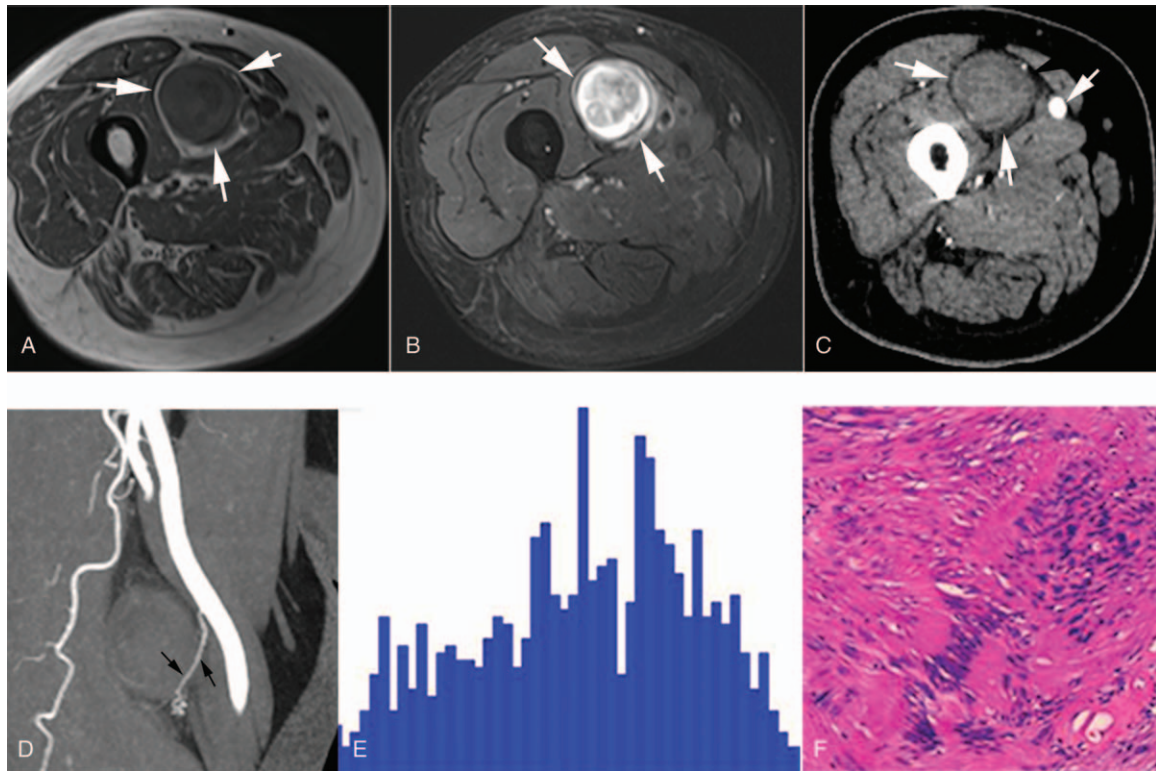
An 84-year-old man with a right thigh mass. T1 and T2-weighted MR images depicted the tumor (A, B, arrows). CTA was performed to better delineate tumor involvement of the adjacent femoral artery. The CTA image was superior to MR in confirming the lack of arterial invasion (C, arrows). The tumor feeding artery was also identified on a reconstructed maximum intensity projection CTA image (D, arrows). Kurtosis, skewness, and inhomogeneity derived from the histogram (E) were 0.15 , 0.21 , and 0.23 , respectively. The pathology showed a schwannoma (F). CTA=computed tomography angiography.
